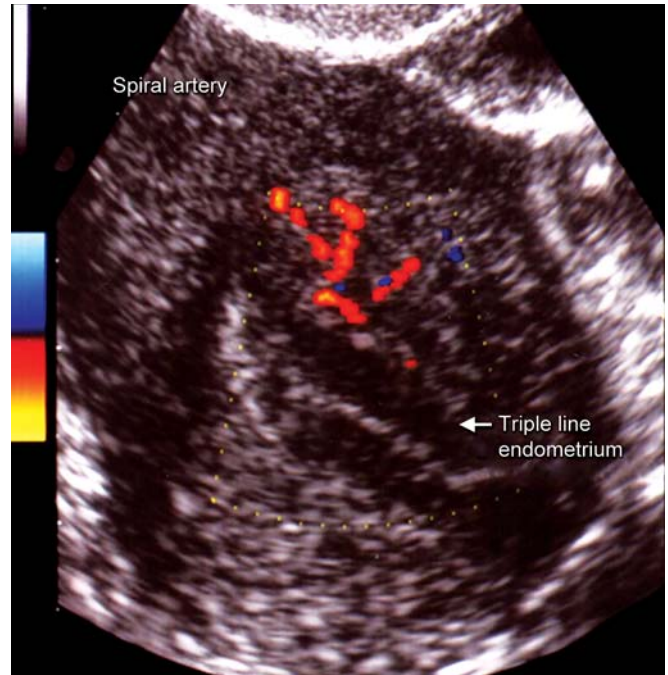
Image recorded by 2D color Doppler sonography showing blood flow in spiral arteries
